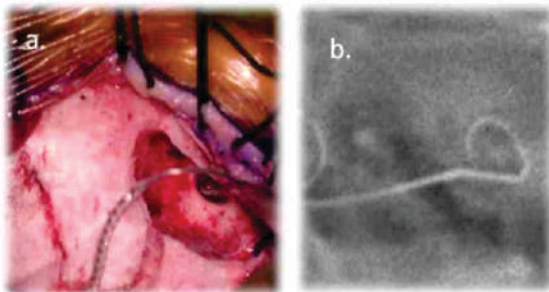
a) Cochlear Implant electrode insertion, b) Post opt X-Ray of temporal bone
